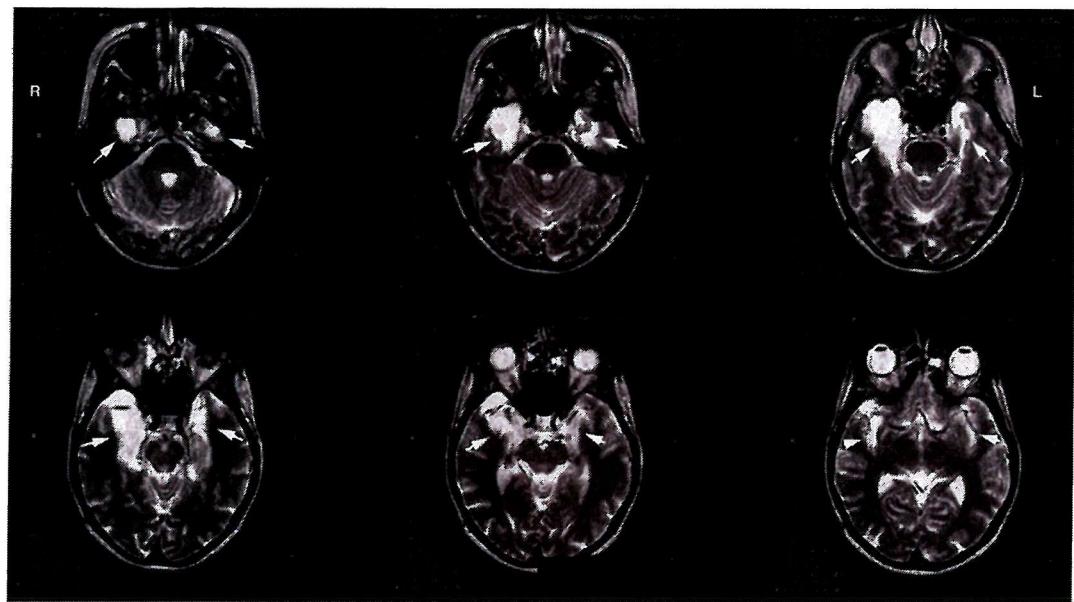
MRI scan of JN's brain showing six horizontal slices through the temporal lobes showing lateral temporal lobe damage (see text for further details).
